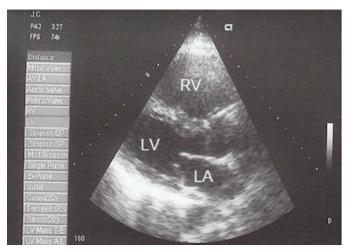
Transthoracic echocardiography before pulmonary endarterectomy: dilated right ventricle. [RV right ventricle, LV left ventricle, LA left atrium]
